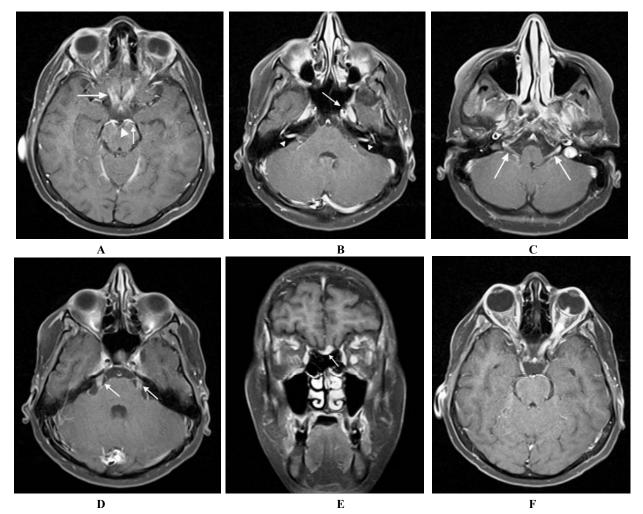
Cranial MR imaging during diagnostic and therapeutic work-up. Axial post contrast brain MRI shows enhancement of chiasma and both optic nerves sheet (large arrow), 3<sup>th</sup> cranial nerve (arrow head) and midbrain pial enhancement (small arrow) (A); bilateral 7&8<sup>th</sup> cranial nerves (arrow heads) and Mechel's cave enhancement (arrow) (B); 9<sup>th</sup>,10<sup>th</sup>,11<sup>th</sup>,12<sup>th</sup> cranial nerves complex enhancement (arrows) (C); both 5<sup>th</sup> cranial nerves enhancement (arrows) (D); coronal MRI of frontal lobe shows bilateral 1<sup>st</sup> cranial nerves which is more prominent in the left side (arrow) (E); axial post contrast image demonstrate left optical nerve sheet enhancement in its entire course (tram-tract like) and retinal tumor enhancement (F).
